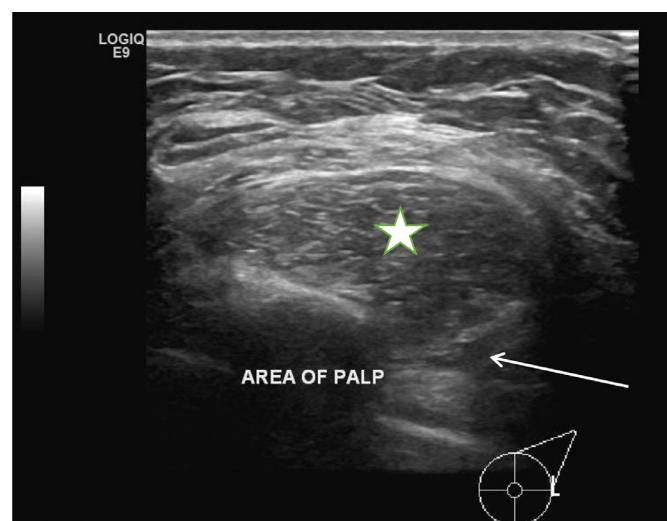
Left breast ultrasound showed submuscular/intramuscular oval heterogeneous mainly hyperechoic with a fat content lesion (Asterisk) at the most lateral part of the left axillary tail, at the site of a palpable mass, with extension into the underlying intercostal area (Arrow).
